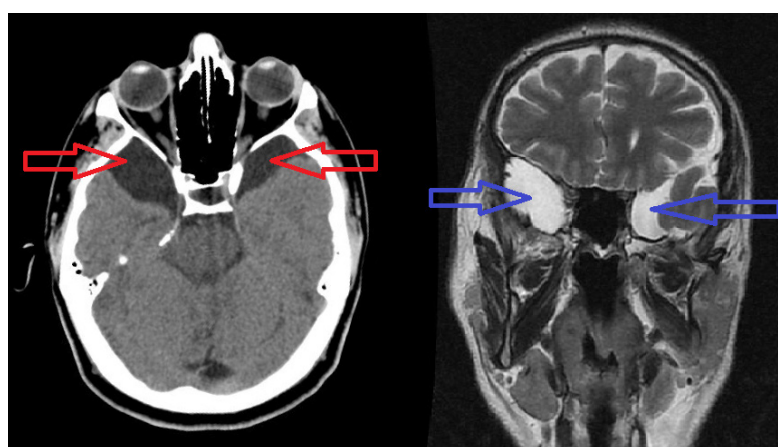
Congenital arachnoid cysts may cause agenesis (red arrows). Differences in their internal dynamics can change the surrounding tissues. Different cyst sizes and temporal lobe agenesis are detected in the heterogeneous bi-temporal arachnoid cyst case. Color differences and heterogeneity in cysts can also be reached qualitatively in MRI examination (blue arrows)
